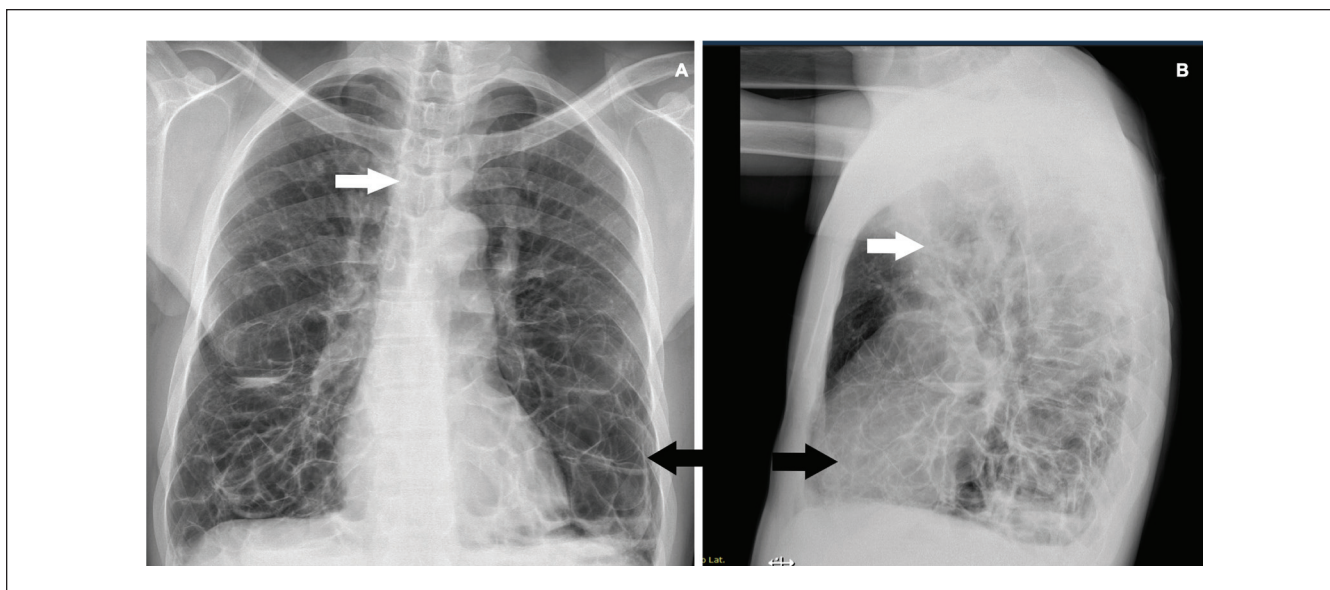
(A and B). Anteroposterior and lateral chest X-ray. Tracheal dilatation (white arrows) associated to thin-walled cystic images (black arrows) in the lower two thirds of both lungs, presence of several air fluid level, with improvement compared with initial chest X-ray.
